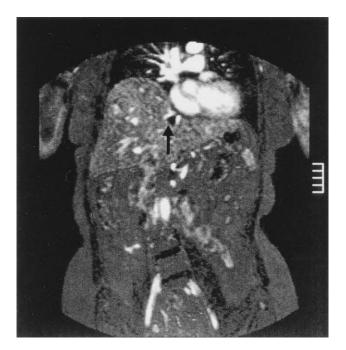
CT scan of the abdomen. The mass (*arrow*) is occupying the proximal portion of the left and middle hepatic veins and compressing the inferior vena cava. There is no involvement of the right hepatic vein.
